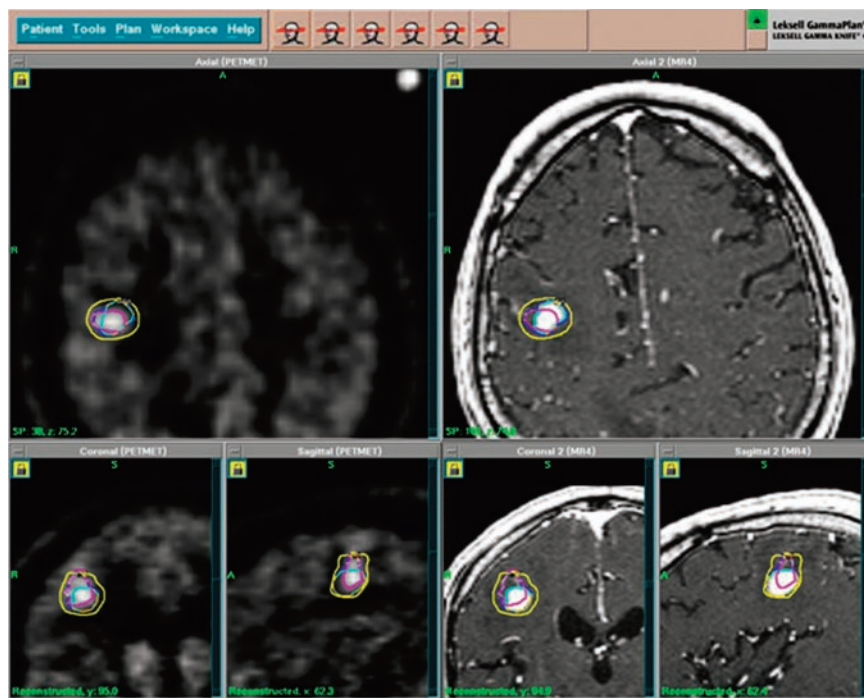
Example of LGK radiosurgical planning using combined PET (^{11}C -methionine) and MRI in patient with local recurrence of metastasis, previously treated with radiosurgery. Tumor volume is defined separately on PET (purple line, left images) and MRI (light blue line, right images); the 2 volumes project partially in different areas (class II). Final target volume (dark blue line) includes entirely both PET and MRI volumes (class IIB). Yellow line represents prescription isodose and encompasses target volume.
